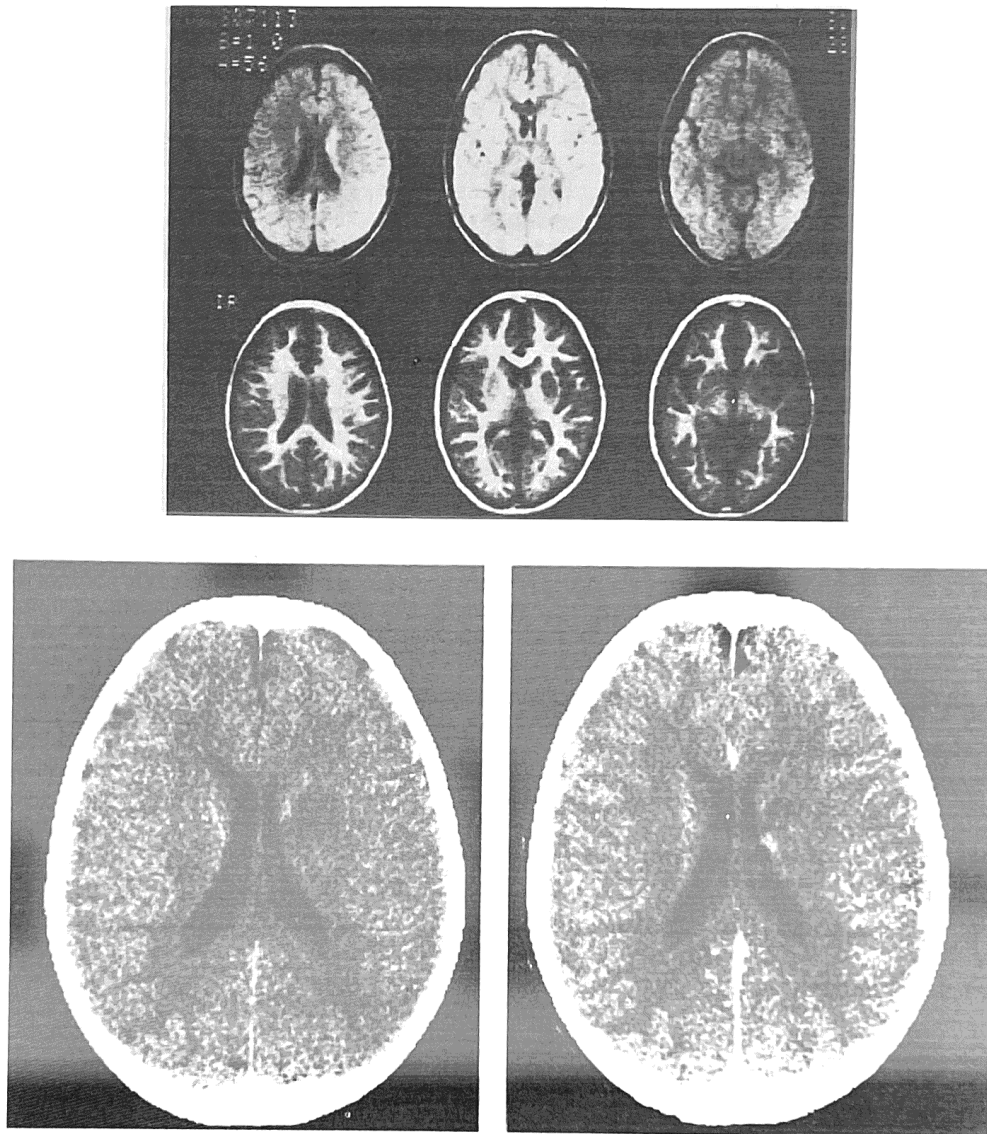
Transverse NMR images through the head of a patient with a left basal ganglion infarct. The top row are spin echo images; the bottom row are inversion recovery images. The left images are the most cephalic. The lesion is best seen in the center plane. It appears as an area of increased intensity in the spin echo image and as an area of decreased intensity in the inversion recovery image. The lesion is not as well seen in the corresponding CT scan (pre and post contrast injection).
